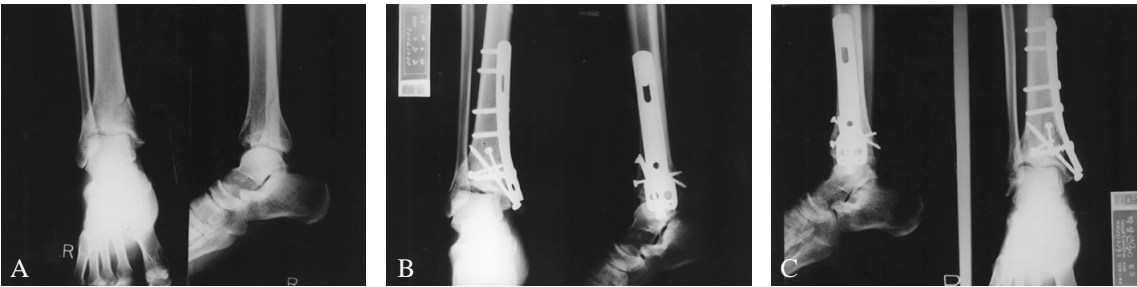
A 47-year-old male has broken his right ankle after a fall from a height (A). He underwent an operation for open reduction and internal fixation with a plate and screws for the intra-articular fracture (B). The postoperative radiography in 6 months showed complete union of the fracture (C).
